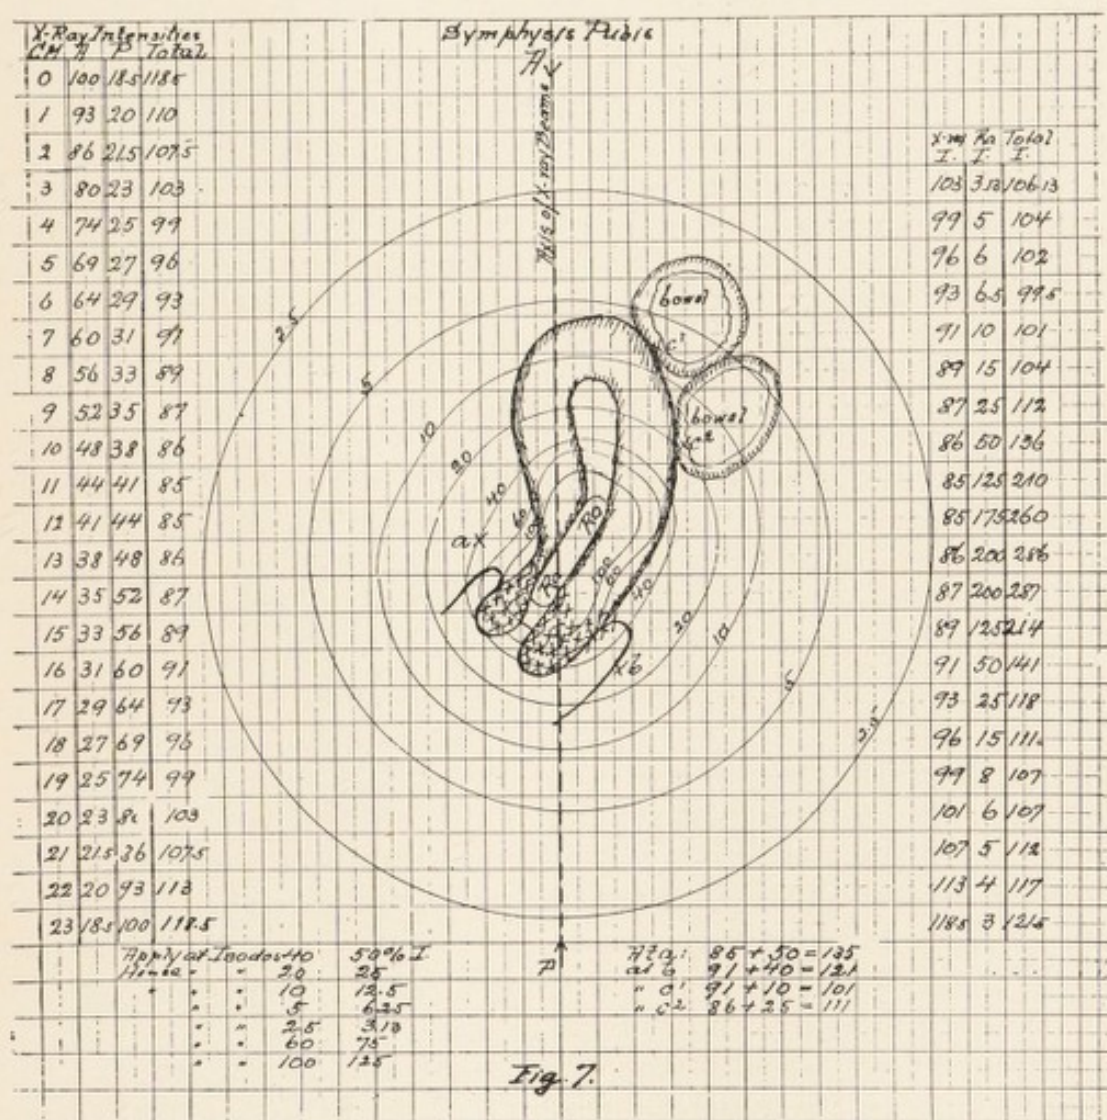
THE CALCULATION OF THE COMBINED X-RAY AND RADIUM DOSE IN A UTERINE CARCINOMA. The anterior posterior diameter is 23 cm. The cervix is 16 cm. beneath the anterior abdominal wall. The uterus is in anteversion. Points a and b denote the posterior vesical and anterior rectal mucosae respectively.
